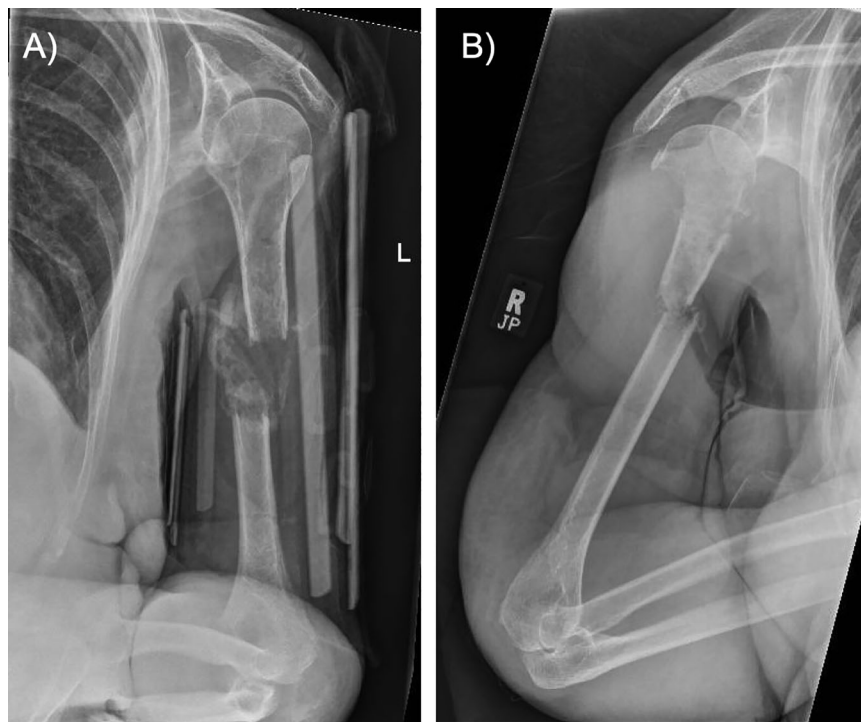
Plain film x-rays demonstrating pathological humeral fractures. (A) Left humeral fracture; (B) right humeral fracture.
